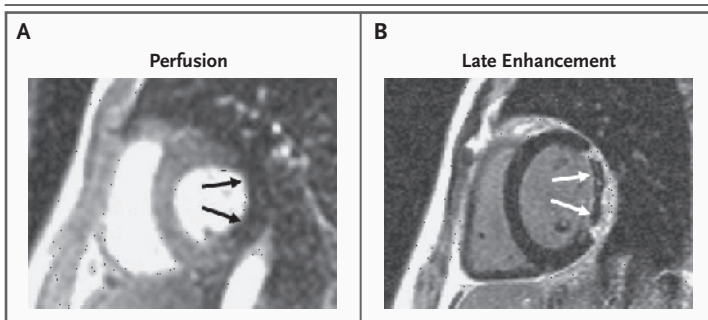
MRI Scans Showing Coronary Microvascular Dysfunction in a Patient with Coronary Artery Disease.
